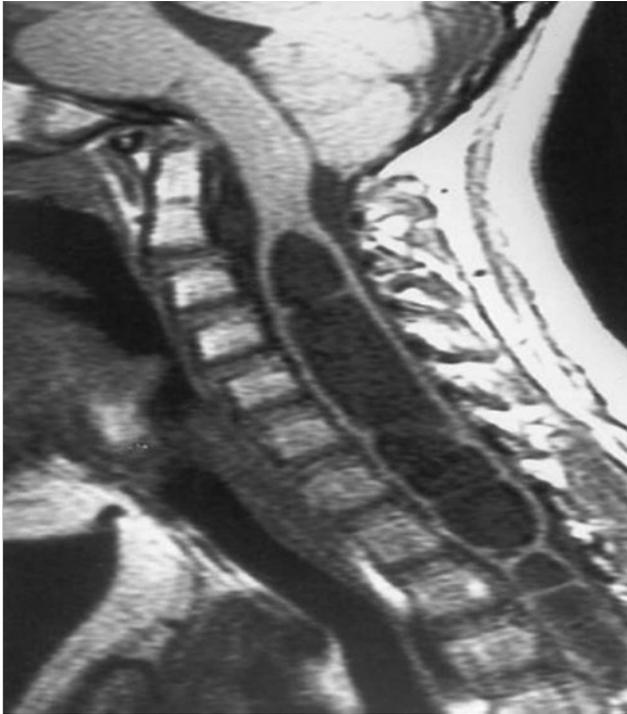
Sagittal magnetic resonance image of a patient with Chiari 1 malformation and a huge syringomyelia. Note the septa (haustri) within the syrinx.
